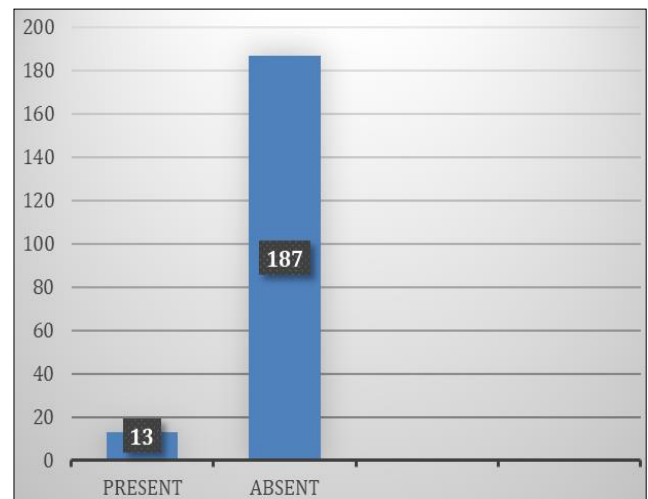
Number of patients with posterior cruciate ligament injury on MRI (N=200)
